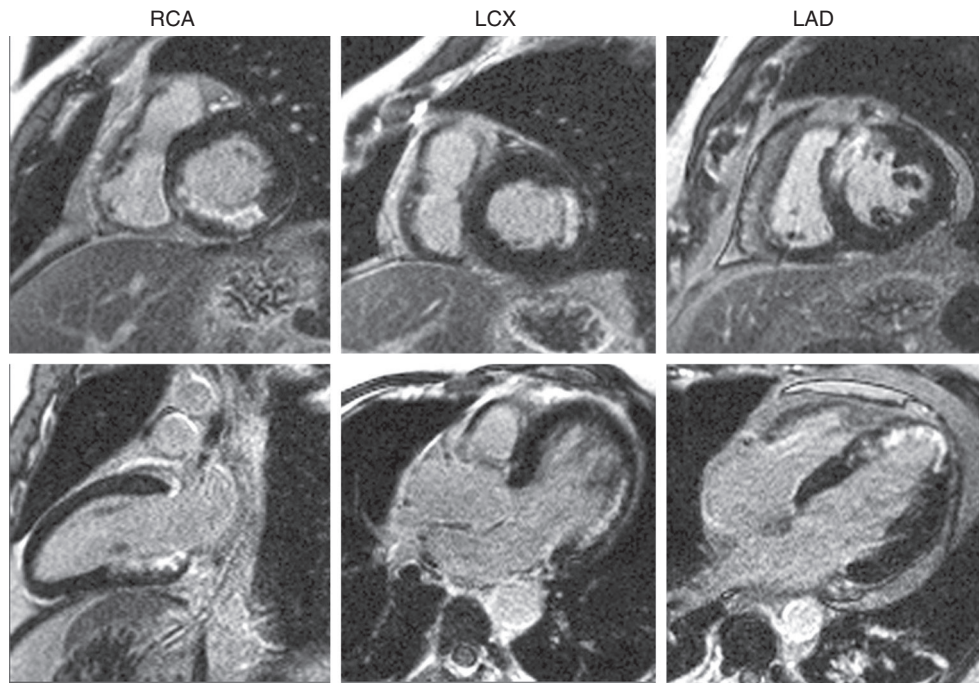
e7 Delayed-enhancement cardiac magnetic resonance images showing infarctions (*bright regions*) in the right coronary artery (RCA), the left circumflex (LCX), and the left anterior descending (LAD) territories. Note that all areas of hyperenhancement involve the subendocardium and are consistent with vascular perfusion territories.
